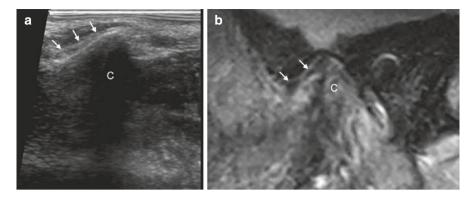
Sagittal sonogram and MR in a 65-year-old female with minimal anterior disc displacement. (a) Mouth-closed sonogram shows minimal anterior disc displacement (arrows) as manifested by the thin zone being anterior to the anterior condylar prominence. (b) MR comparison confirms slight anterior disc displacement (arrows). *C* condyle
